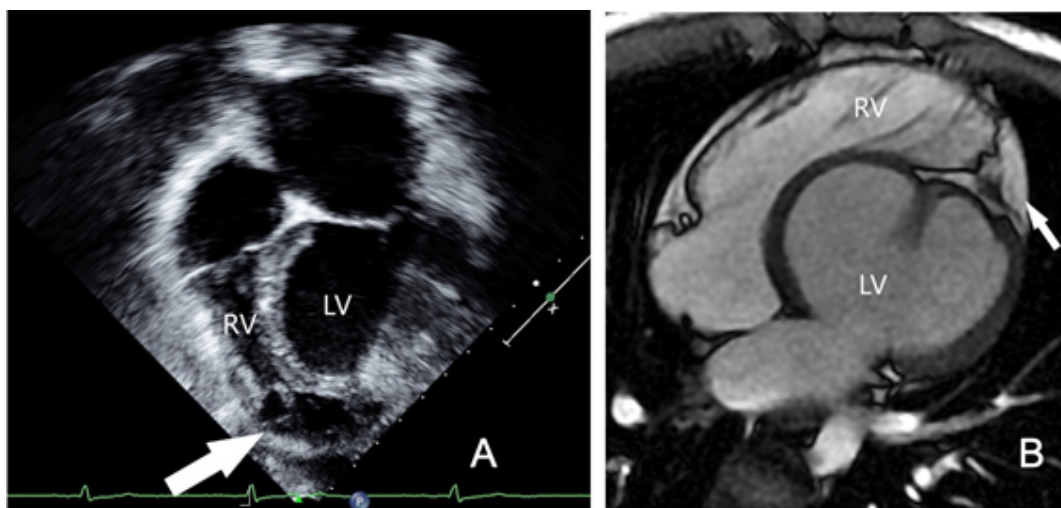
A-Echocardiogram (four-chamber view) showing the right ventricle (RV) (arrow) wrapping the left ventricle (LV). B-Cardiac MRI (four-chamber view) showing spherical LV configuration, fatty material at LV apex (arrow), RV elongation wrapping the deficient LV apex.
